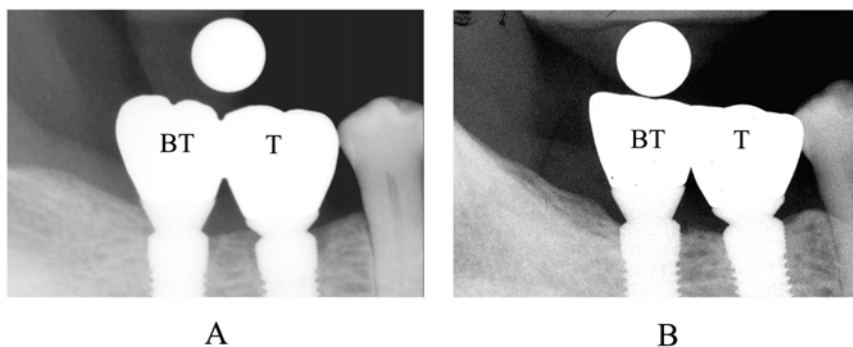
Intra-oral radiographs of implants
